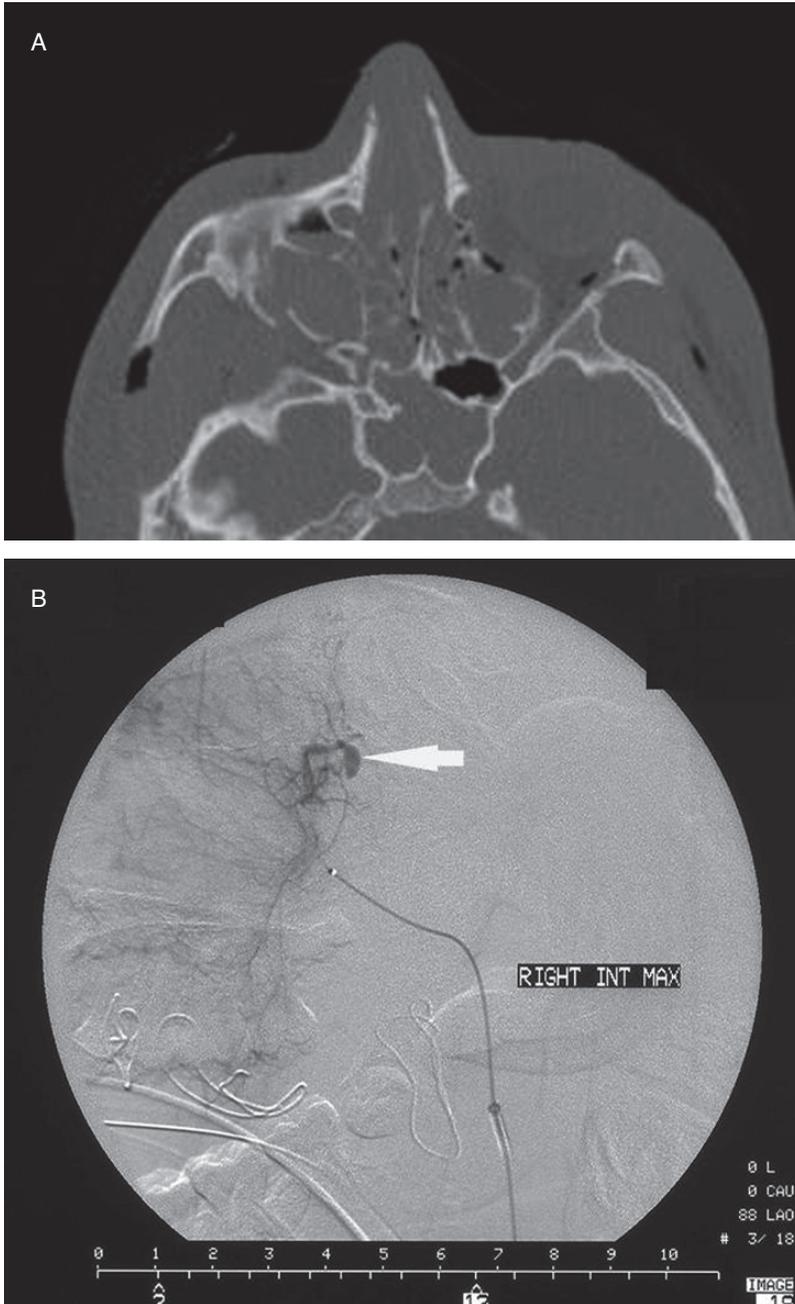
Traumatic pseudoaneurysm. (A) Facial CT showing extensive facial fractures. The patient had uncontrollable transfusion dependent bleeding despite surgical packing. (B) Pseudoaneurysm (white arrow) on an angiogram. (C) Angiogram after coil (black arrow) embolization, with occlusion of the pseudoaneurysm.
